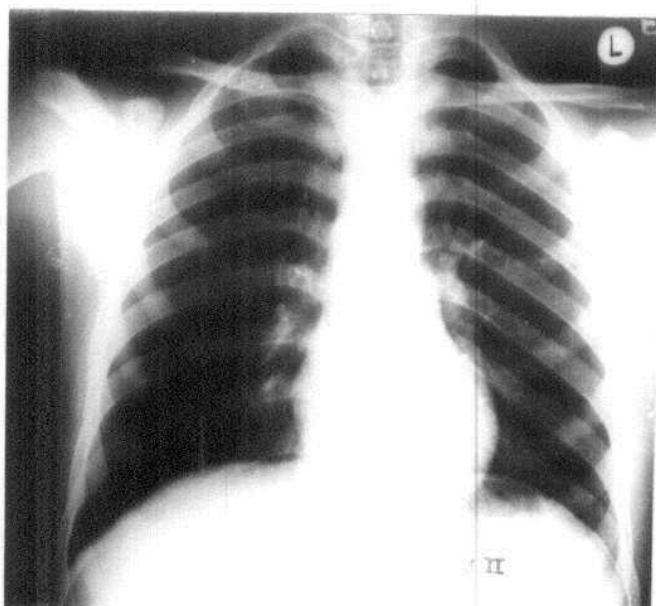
Preoperative chest radiograph for patient No. (8 II): No active lung lesion.
